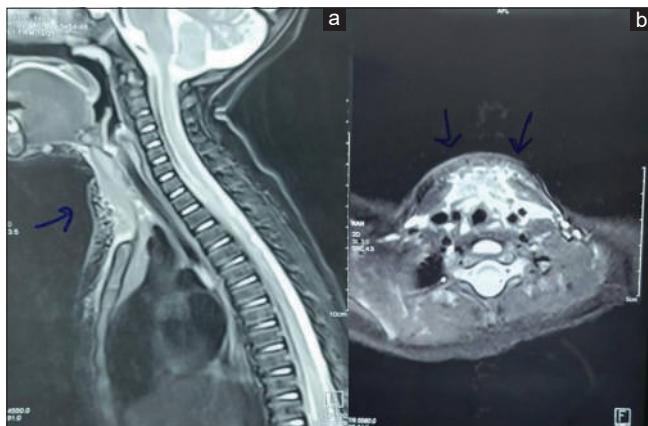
(a and b) Magnetic resonance imaging neck showing edema of the anterior mediastinum, enlarged lymph nodes, and cellulitis suggestive of anterior mediastinitis. The arrows show the cellulitis of the anterior chest wall
